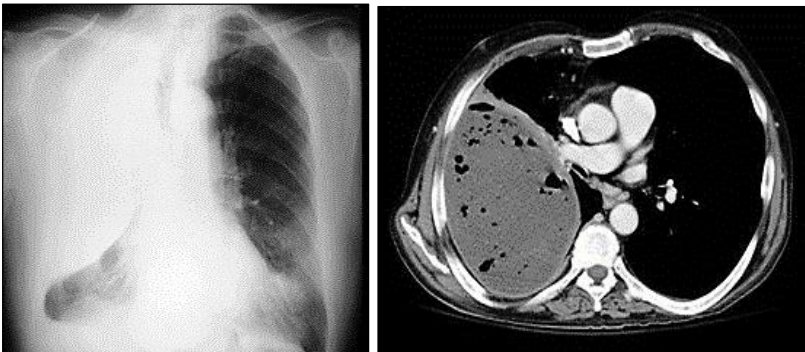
Radiological & CT of Empyema
